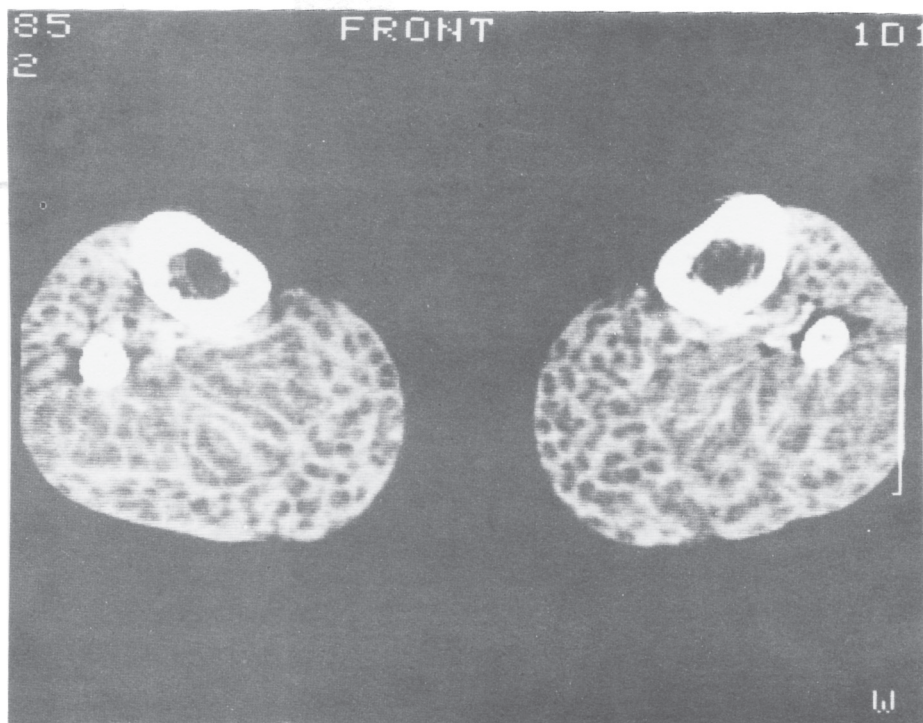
Pre-contrast CT scan of both calves infiltrated with a large number of cysticerci giving a "honey-comb" effect. The scolices within the cyst cannot be easily appreciated here but become clear on magnification.
